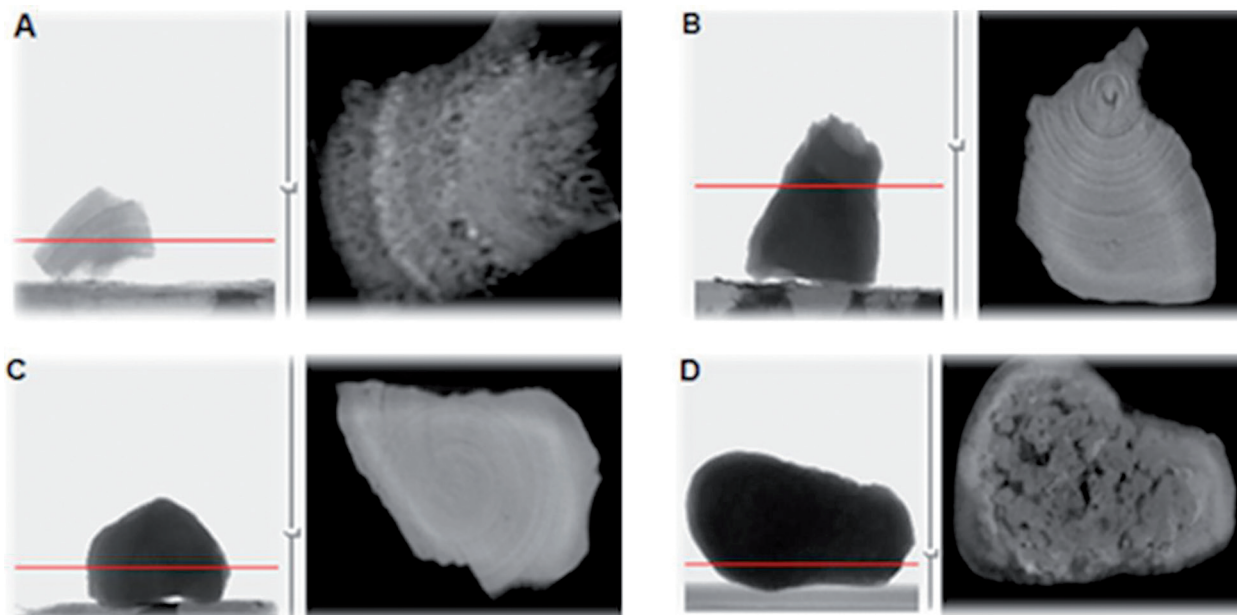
Micro-focus computed tomography images of the stones. The red line shows the cross section of the stones. A: Heterogeneous in appearance but homogeneous in content uric acid stone. B: Homogeneous in appearance but heterogeneous in content uric acid and Calcium oxalate monohydrate (COM) stone. C: homogeneous in both appearance and content a COM stone. D: A highly heterogeneous mixed COM and Calcium oxalate dihydrate stone includes many internal voids.
